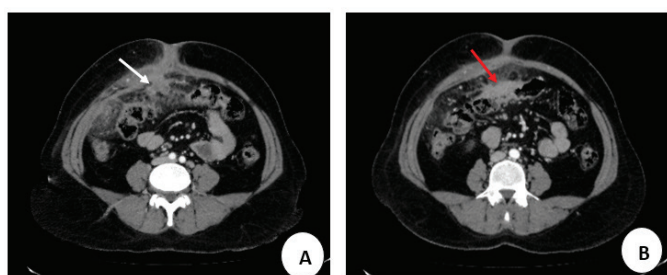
Contrast enhanced CT Abdomen and pelvis (Axial views)
